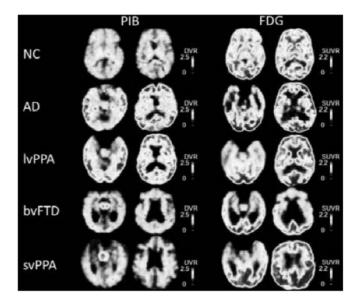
Typical binding of Pittsburgh Compound B (PIB) to amyloid ligand and 18F-fluorodeoxyglucose (FDG) hypometabolism patterns in:
